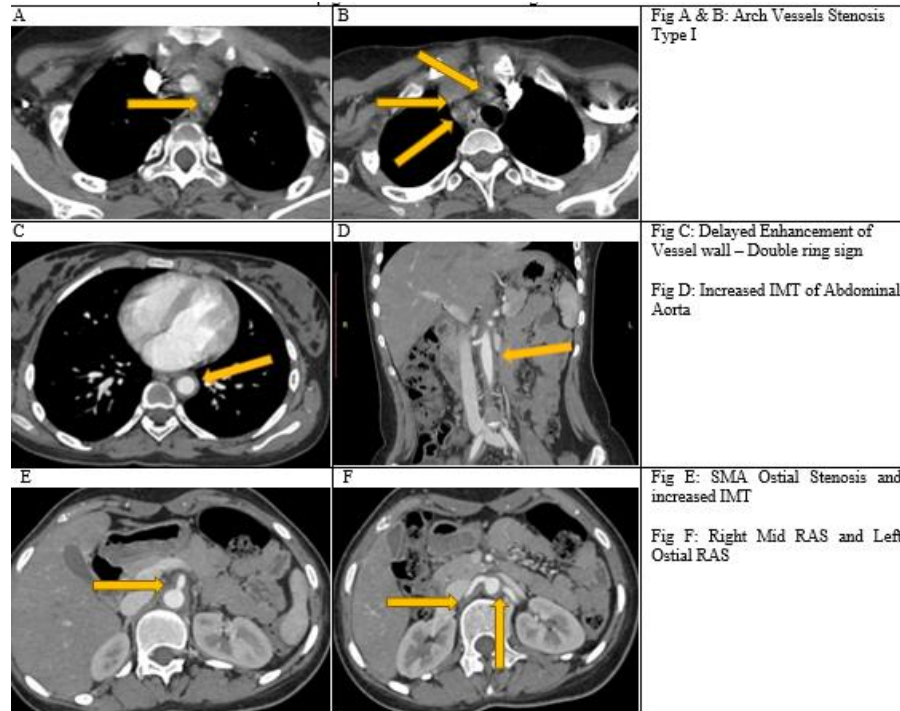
CTA Pictorial Findings of Patient A
